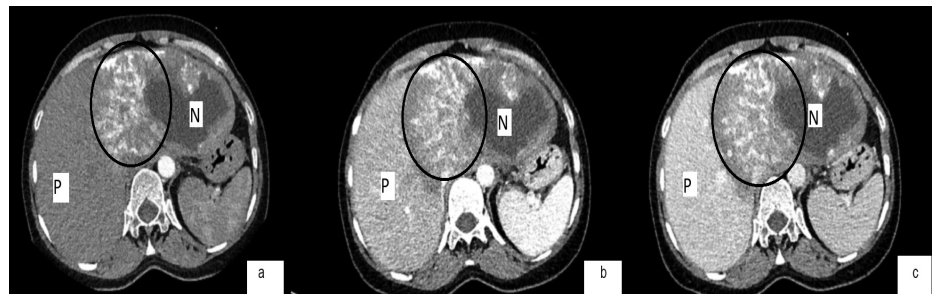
Arterial (a), portal venous (b), hepatic venous (c), axial computed tomography images of a hepatic alveolar echinococcosis with typical calcification pattern (circle), necrotic areas (N), and irregular contours with normal parenchyma (P).
